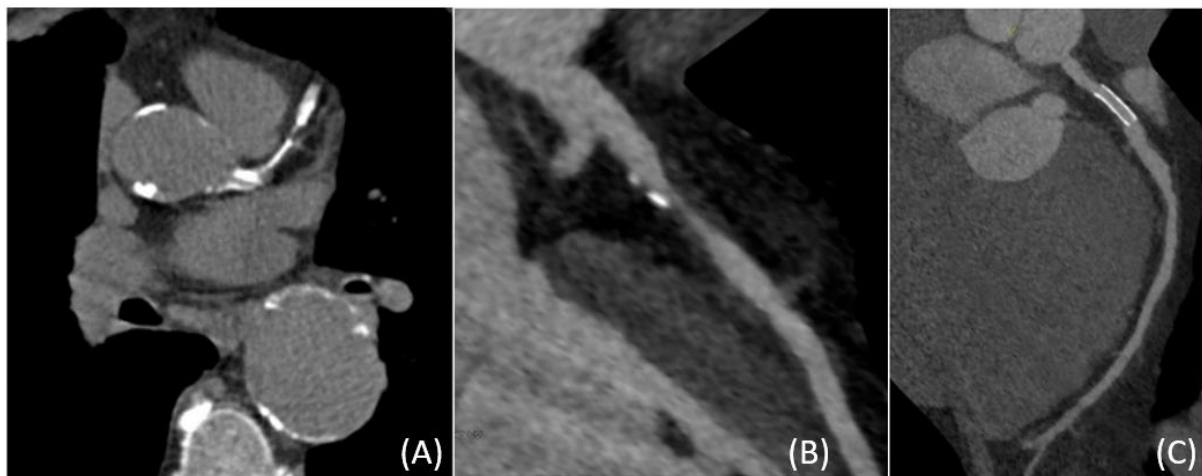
Coronary CT images. Calcification in the left main artery, LAD and aorta is visualised in a native calcium CT scan (A). The CCTA image (B) shows a less calcified lesion with severe stenosis, and a stented vessel after revascularisation is shown in the CCTA image (C).
